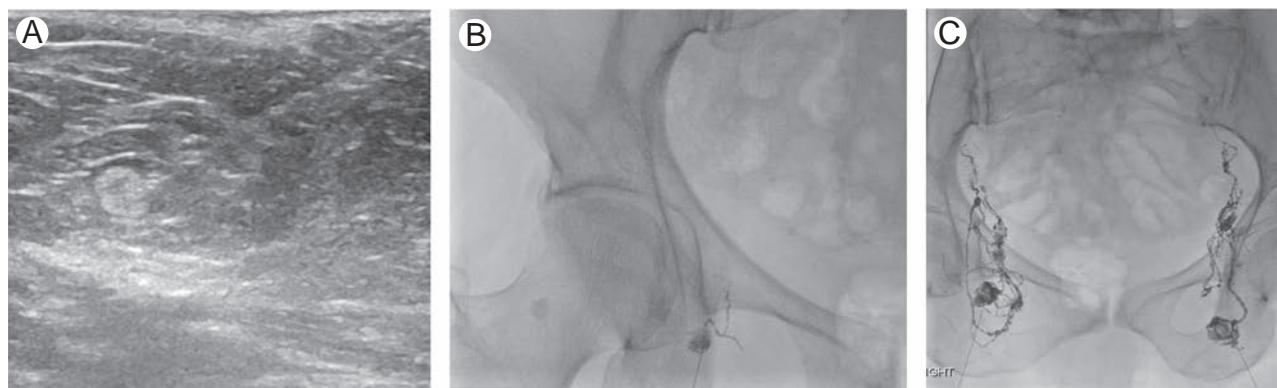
Initial intranodal lymphangiogram. Longitudinal ultrasound image demonstrating the course of the access needle with the tip in an inguinal lymph node, at the junction of the cortex and medulla (A). Initial image showing iodinated oil contrast agent filling a right inguinal lymph node, and the contrast agent beginning to exit the efferent lymphatic (B). Later image after a left-sided lymph node was subsequently accessed, with progression of contrast agent along the iliac lymphatics bilaterally (C).
